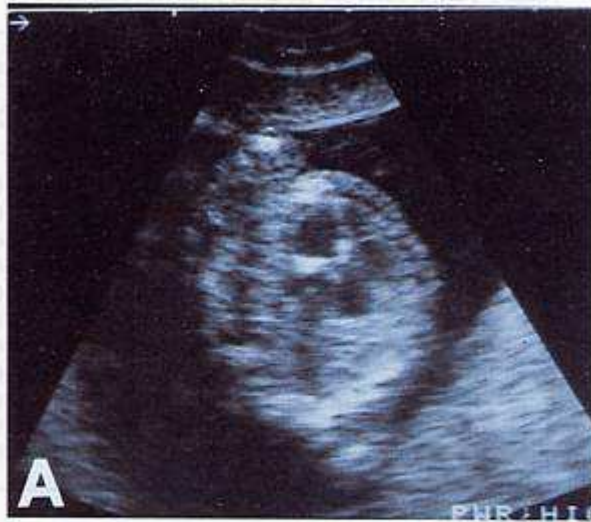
(A) Transvaginal echocardiography of a 14-week gestational age fetus. LV = Hypertrophic left ventricle with mitralic valve and septal anomalies. (B) Same scan in time motion mode
